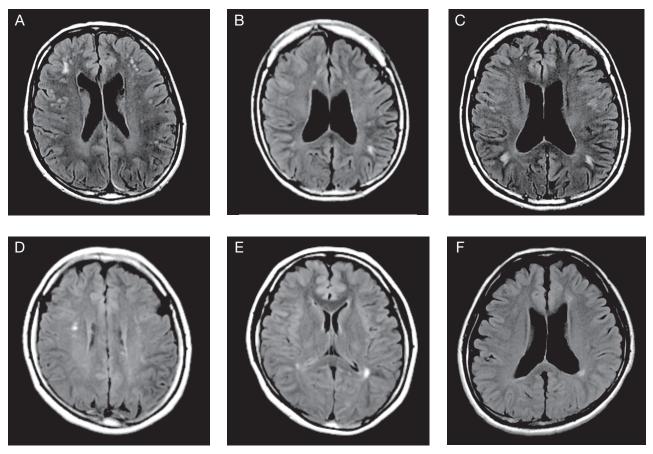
MRI FLAIR images of migraine patients with cerebral white matter lesions (1.5 Tesla, TR: 2000 ms, TE: 125 ms, TI: 2000 ms).
